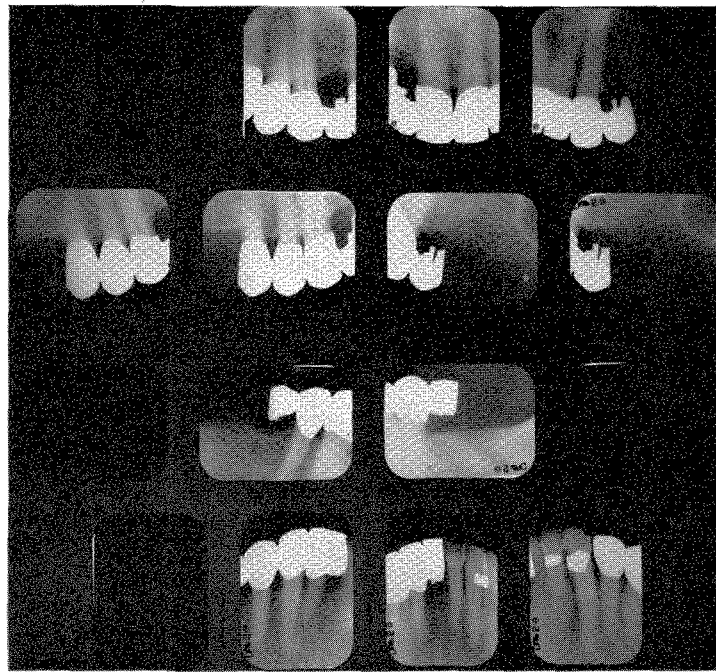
Roentgenograms taken in January, 1961. The patient was 70 years old.
